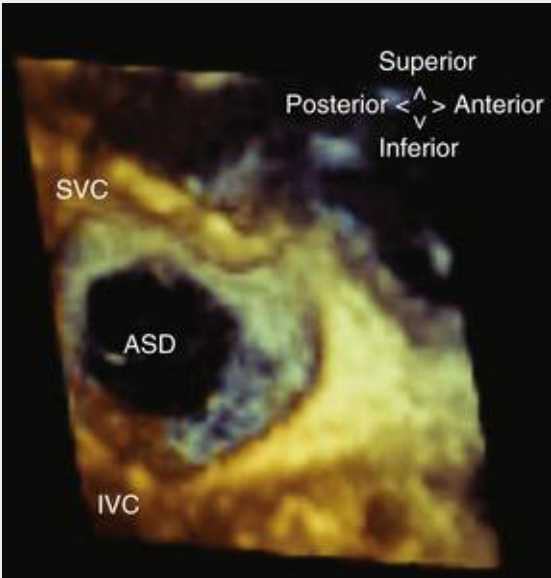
Three-dimensional secundum ASD: This real-time 3D echocardiographic image obtained by TEE demonstrates the rims of a large secundum atrial septal defect, as seen from the right atrium. ASD, atrial septal defect; IVC, inferior vena cava; SVC, superior vena cava.
